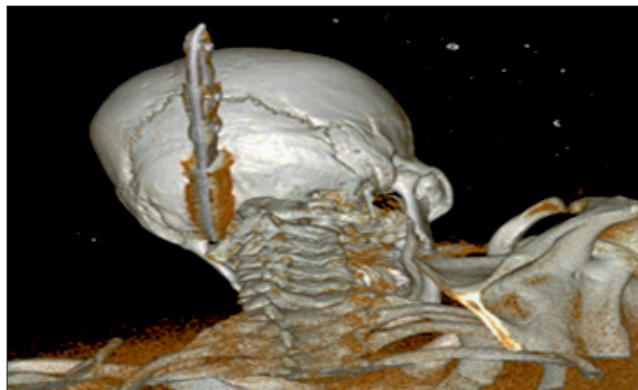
CT Brain 3D reconstruction posterior view of the foreign body in situ
